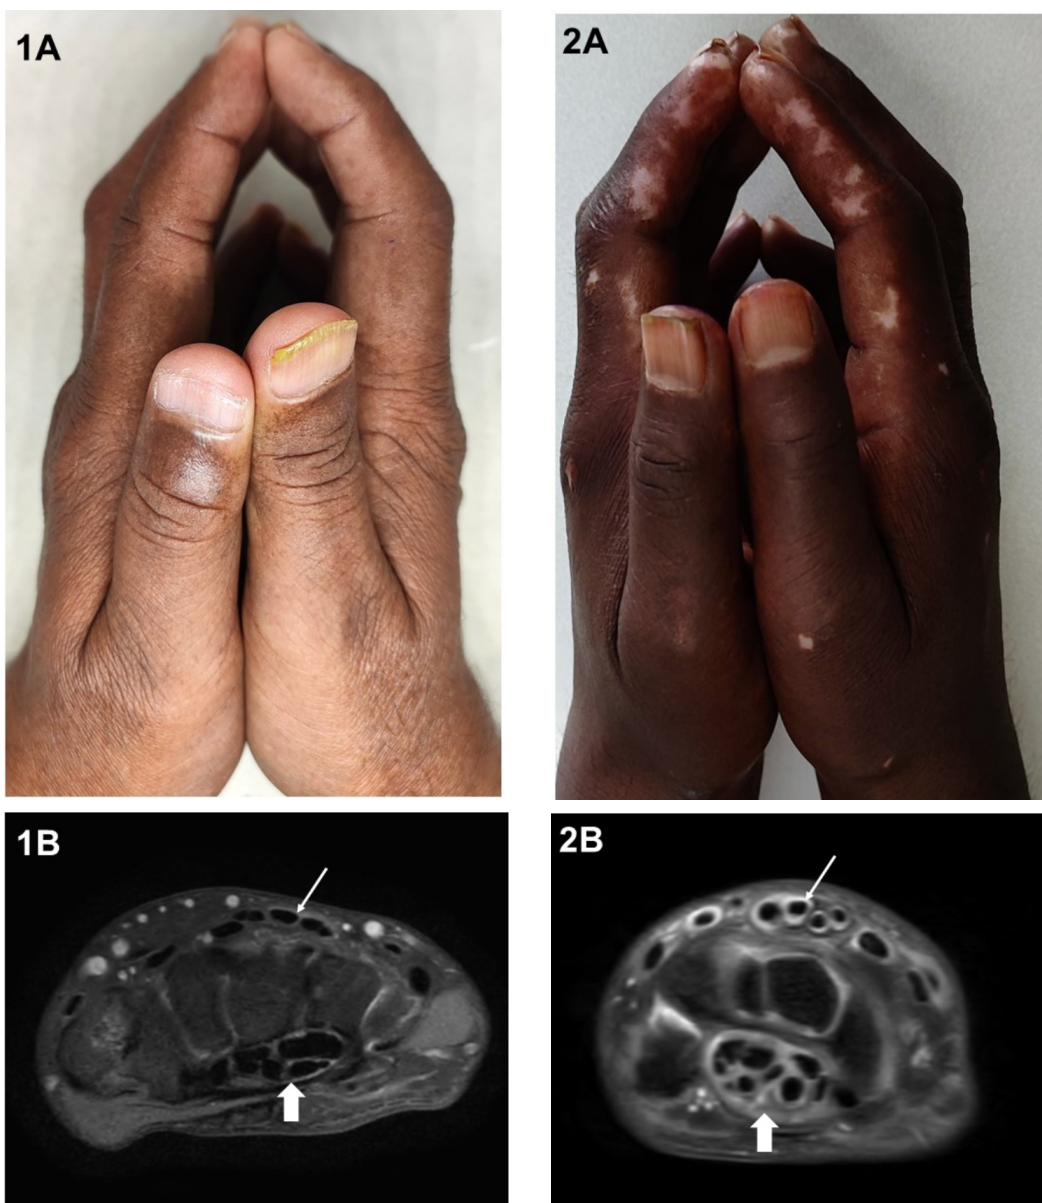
(A-B). Prayer sign in a patient with type 2 diabetes mellitus; and Figure 2 (A-B) a patient with systemic sclerosis. MRI images show Axial proton density fat-saturated (PDFS) magnetic resonance imaging (MRI) of patient with contrast in tenosynovial thickening on the flexor aspect (broad arrows) and extensor aspect (narrow arrows).
